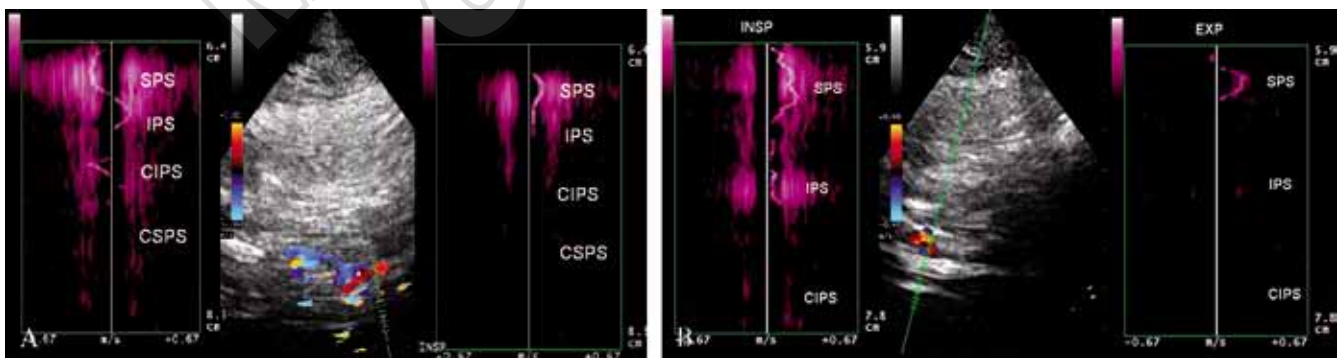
Intracranial reflux detected by multiangle Doppler.
